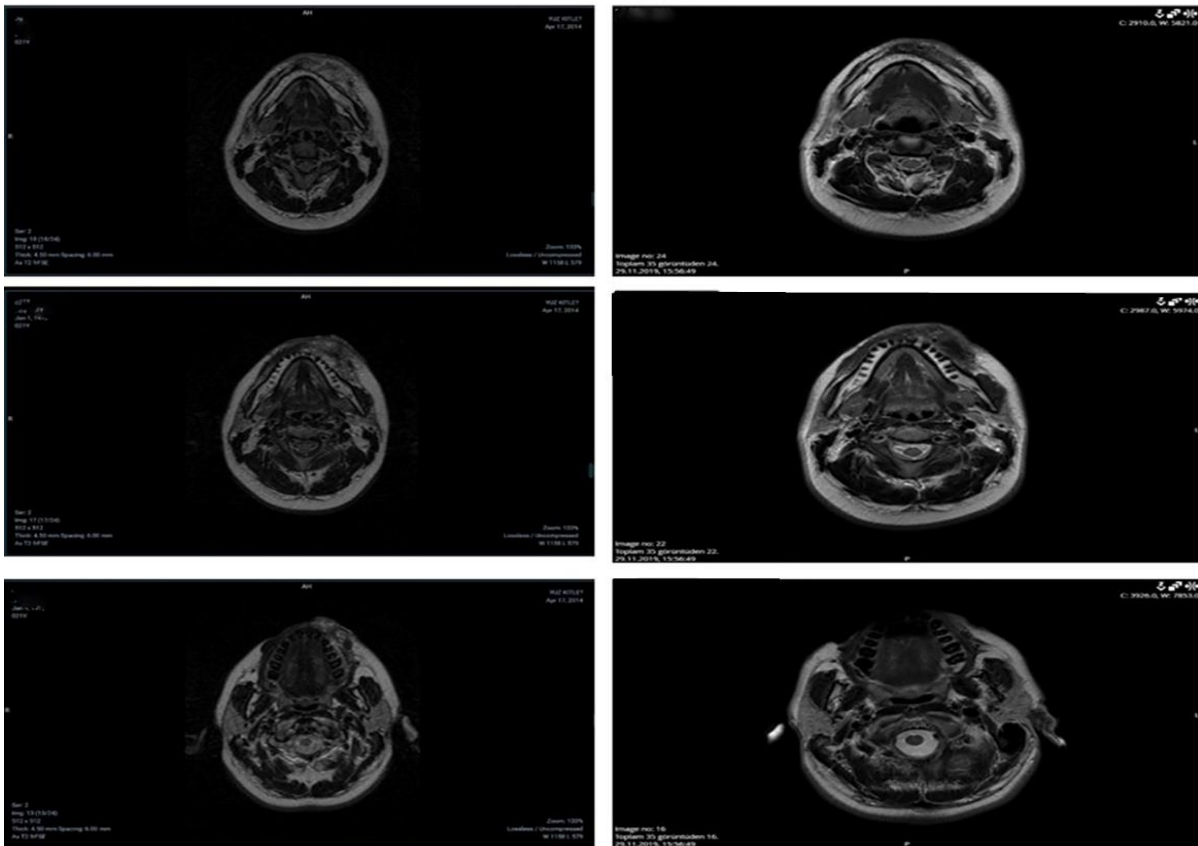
MRI of the patient. MRI before receiving RT in column dated 2014: 5.5x2.5cm heterogeneous lymphangioma in subcutaneous T1W and T2Asers in the left lower lip. In the column dated 2019, MRI after receiving the second series of RT: the lesion diameter was measured as 28x18mm.
